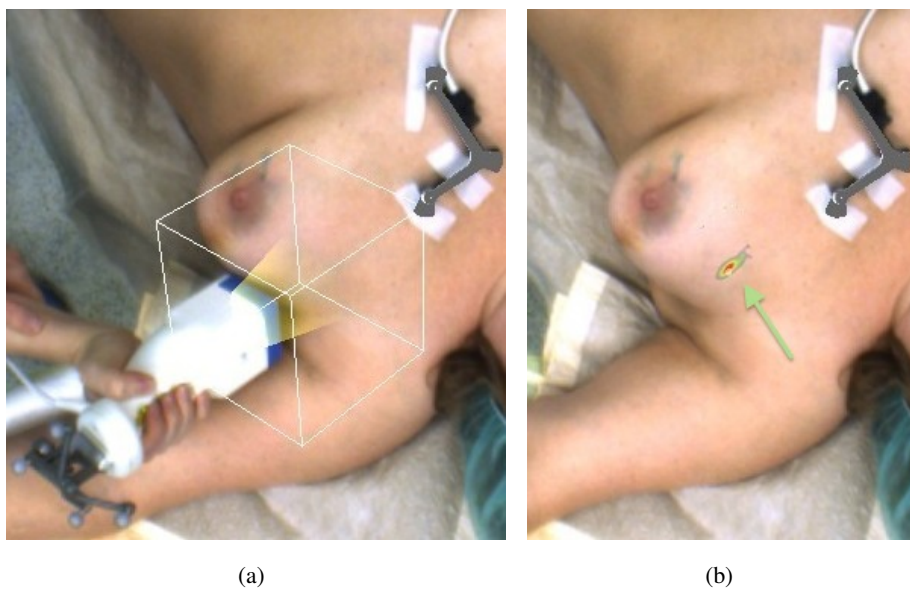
Patient scan inside the operating room. (a) Freehand SPECT acquisition and augmentation of the scanning volume (VOI). (b) Resulting Freehand SPECT reconstruction overlaid on the patient.
